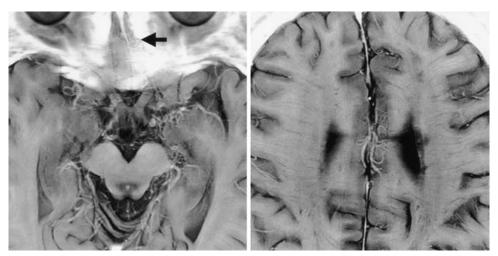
Axial MR images obtained in a 37-year-old woman with moyamoya disease. Note visualization of linear structures throughout the white matter (medullary streaks) as well as fine moyamoya vessels (*arrow* identifies ethmoid moyamoya vessels).
